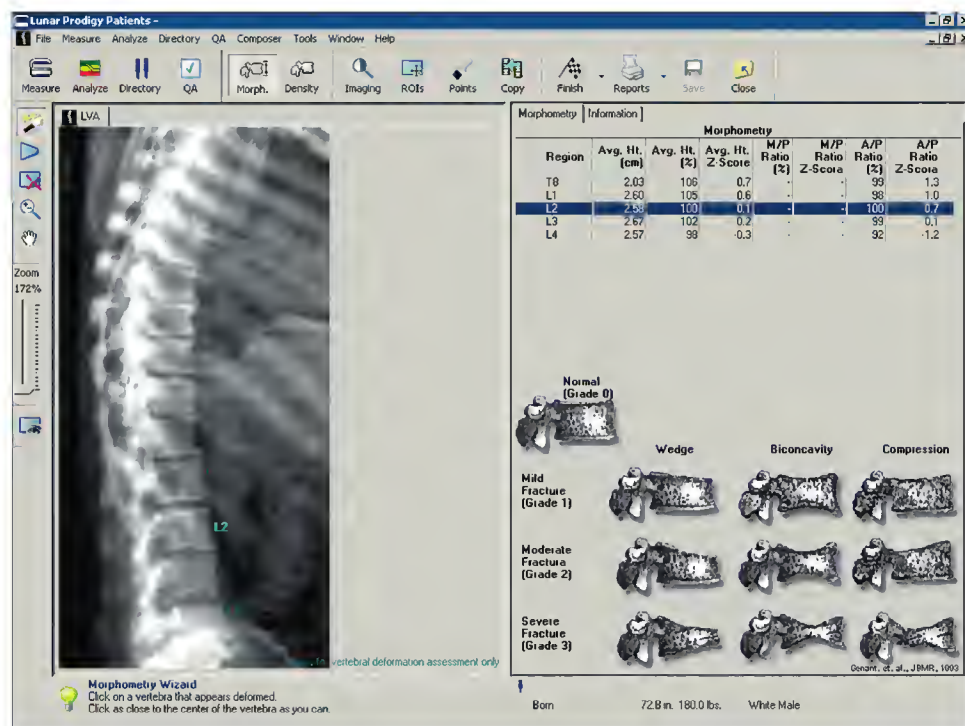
Lateral spine dual-energy x-ray absorptiometry (DXA) for assessment of vertebral fractures in a 66-year-old man. This study was performed with a GE Lunar Prodigy DXA device. No vertebral deformities are seen. The AAC-8 score is 0. Small osteophytes are visible anteriorly at the T8-T9 level. The Genant semiquantitative grading system is shown in the lower right portion of the image.
